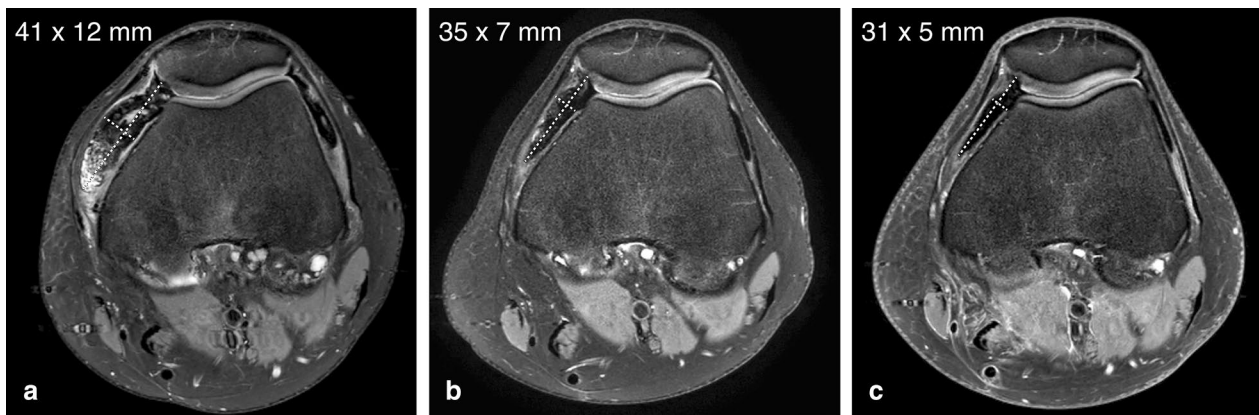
MRI findings after treatment of D-TGCT with a CSF1R inhibitor. a Axial PD SPAIR images in a patient with intra-articular D-TGCT. Baseline image showing a target lesion (two axial diameters measured according to modified RECIST, dotted lines) in the medial suprapatellar recess. Note a smaller similar lesion in the lateral suprapatellar recess. b After 8 weeks on CSF1R-inhibitor therapy, the tumour showed a significant decrease in size and signal intensity. Joint effusion was resolved (not shown). The patient experienced improvement in symptoms of pain and swelling. c After 36 weeks, residual low signal intensity hemosiderin “scars” remained both in the medial and lateral suprapatellar recesses
